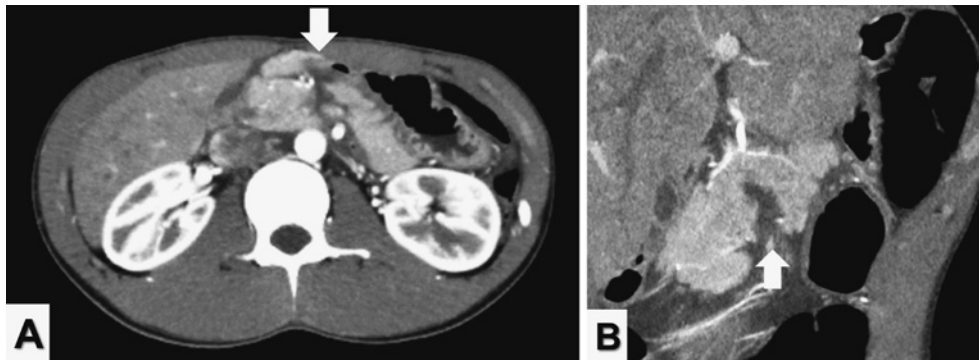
Computed tomography (CT) findings: (A) axial and (B) coronal images
